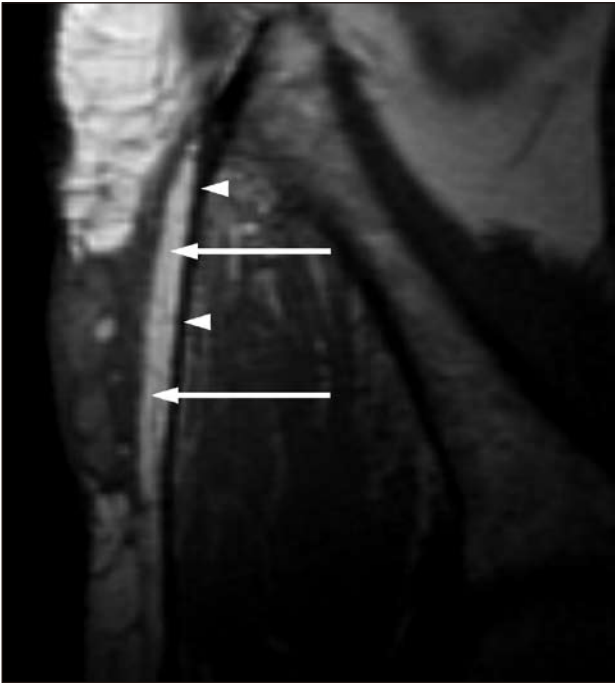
Coronal T1-weighted magnetic resonance image showing a well-preserved fat plane (arrows) between the mass and underlying iliotibial band (arrowheads).
